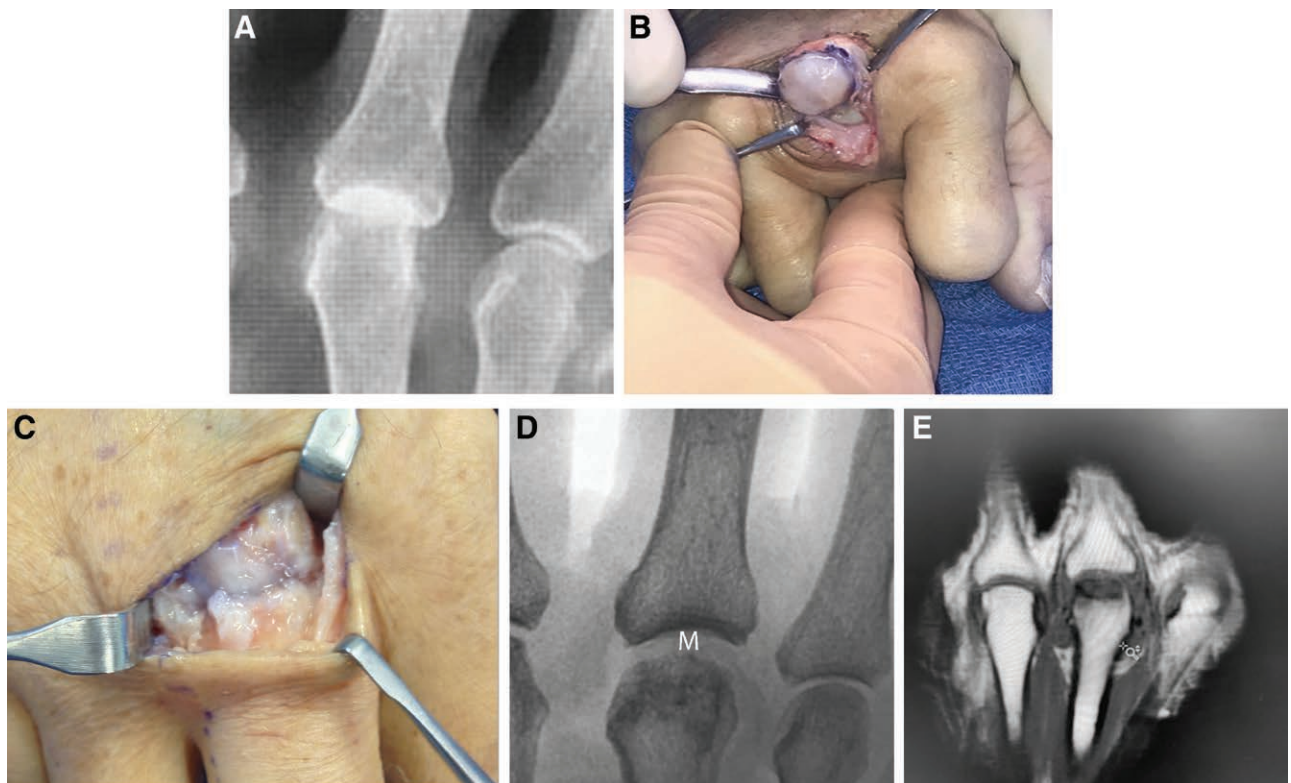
Intraoperative sequence for MCP arthroplasty of the right long finger in a 57-year-old woman with osteoarthritis. A, Preoperative radiograph demonstrating osteoarthritic changes. B, Inset of the allograft over the decorticated proximal aspect of the MCP joint. Note the preserved convexity of the metacarpal head. C, Reduced joint. D, Postoperative radiograph highlighting joint space preservation with the meniscal allograft, marked “M.” E, Postoperative MRI demonstrating the meniscal allograft.
